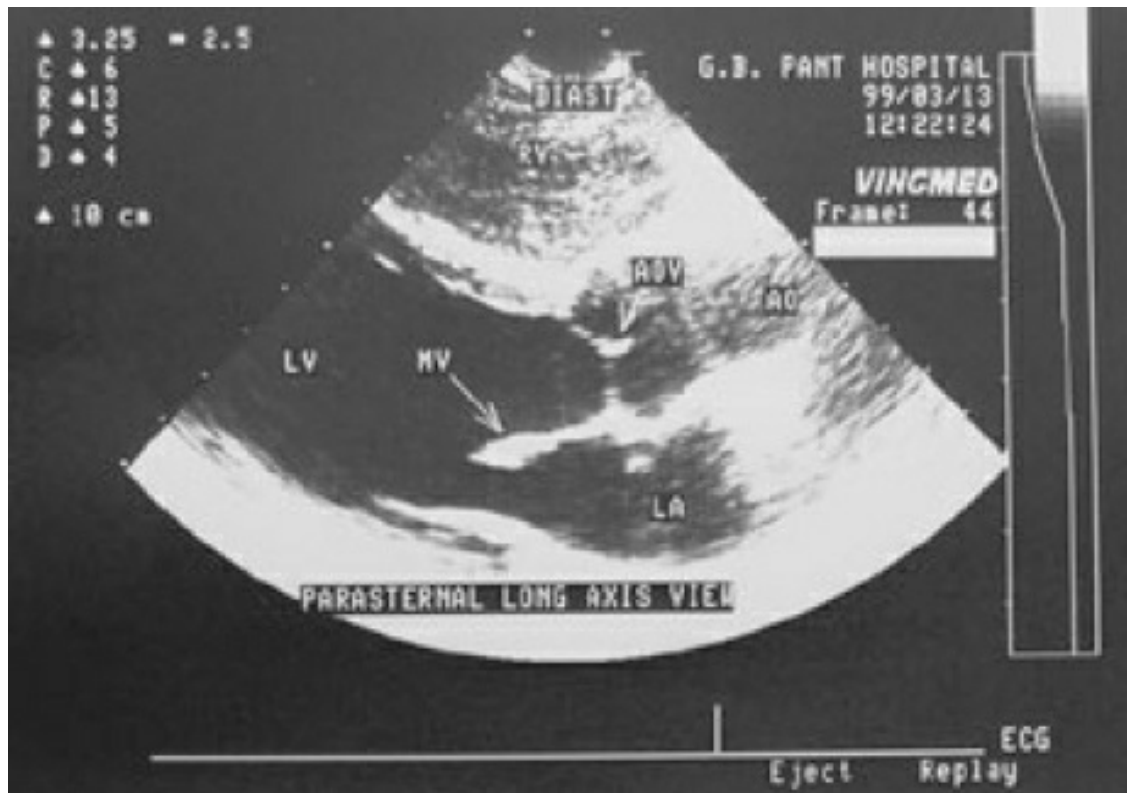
A typical 2-D echocardiogram showing parasternal long axis view (RV: right ventricle, LV: left ventricle, MV: mitral valve, LA: left atrium, AOV: aortic valve, AO: aorta).
